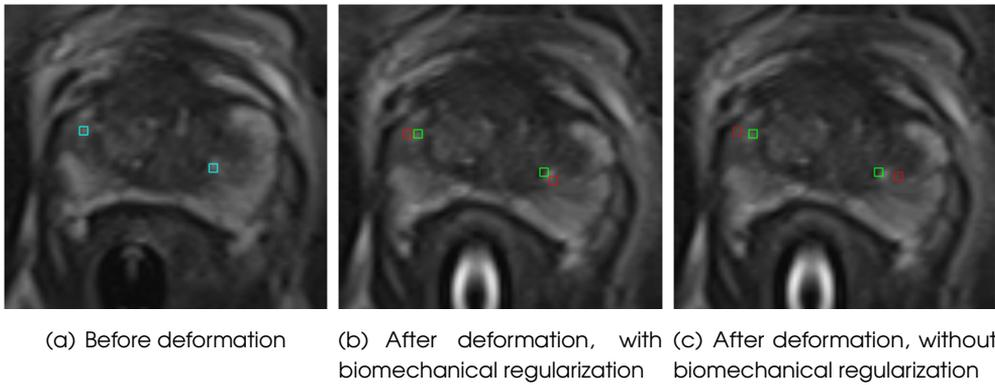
T2-weighted images of the prostate. (a) The left image shows the prostate before deformation with internal anatomical prostate landmarks in blue. (b)–(c) The middle and right images show the prostate after deformation with the real positions of the corresponding landmarks indicated in green and the registered landmarks in red after non-rigid surface-based registration (b) with and (c) without biomechanical regularization.
